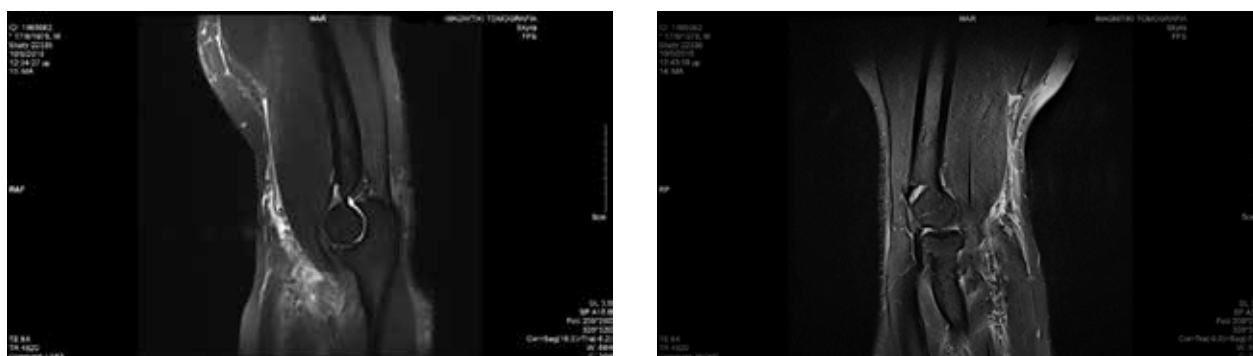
a* T2 weighted MRI showing retraction of the right biceps distal tendon stump at 9cm from the radial tuberosity. *b*. T2 weighted MRI showing retraction of the left tendon stump at 5,2cm.
